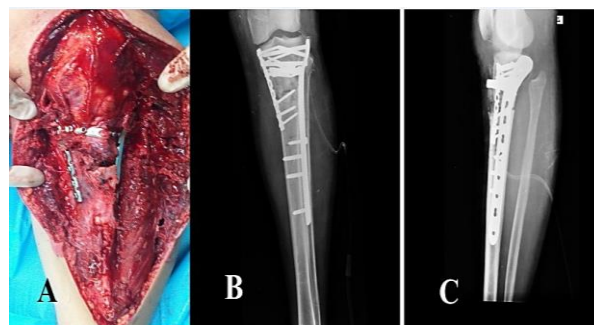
Intraoperative photograph of the final construct (A). Early anteroposterior (AP) (B) and lateral (C) postoperative radiographs
